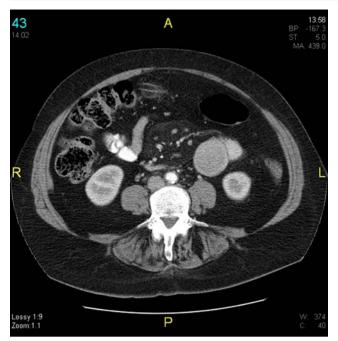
CT scan showing intussusception in the proximal jejunum.
